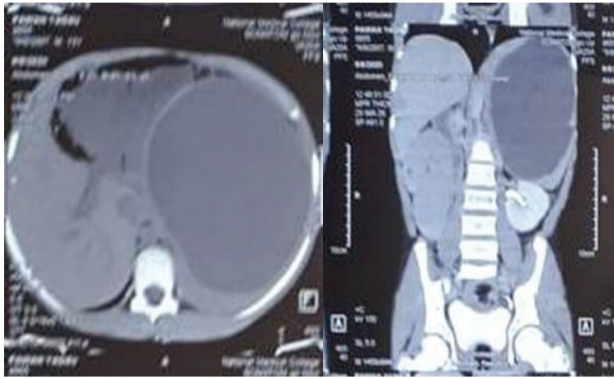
Abdominal CT scan shows a large splenic cyst. Axial view and Coronal view
